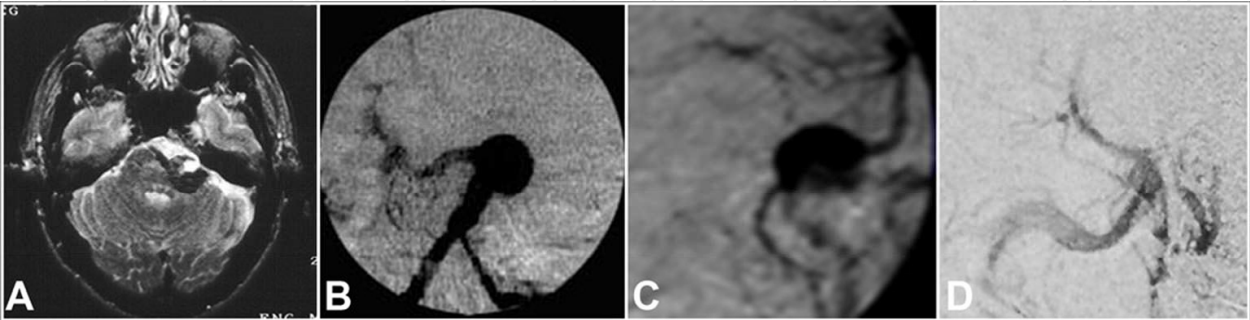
Preoperative CT scan (A), preoperative angiography (B,C) and intraoperative angiography (D) of a very large aneurysm located at level of the vertebro-basilar junction and prevalently located in the lower portion of the left ponto-cerebellar angle because of the dolichototis deviation of the vertebrobasilar arteries.
